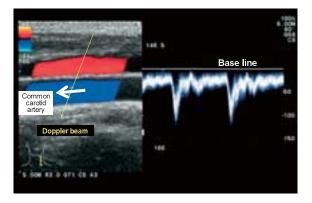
Representation by pulse Doppler method (left: the distal side)
